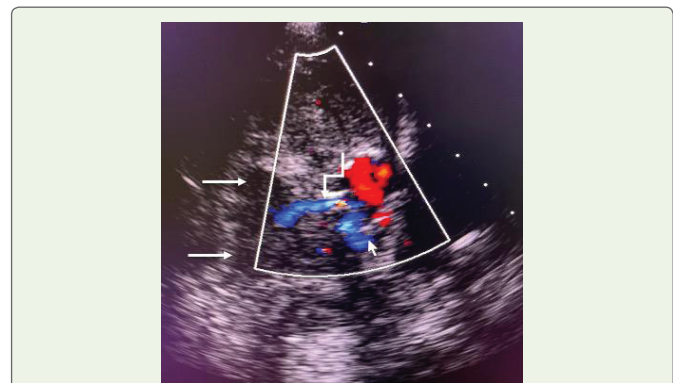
Transoesophageal echocardiogram (TEE) showing a large anechoic collection (white arrows) adjacent to the prosthetic valve with characteristic jet through the rent in the ascending aortic wall (curved white arrow representing the jet).
